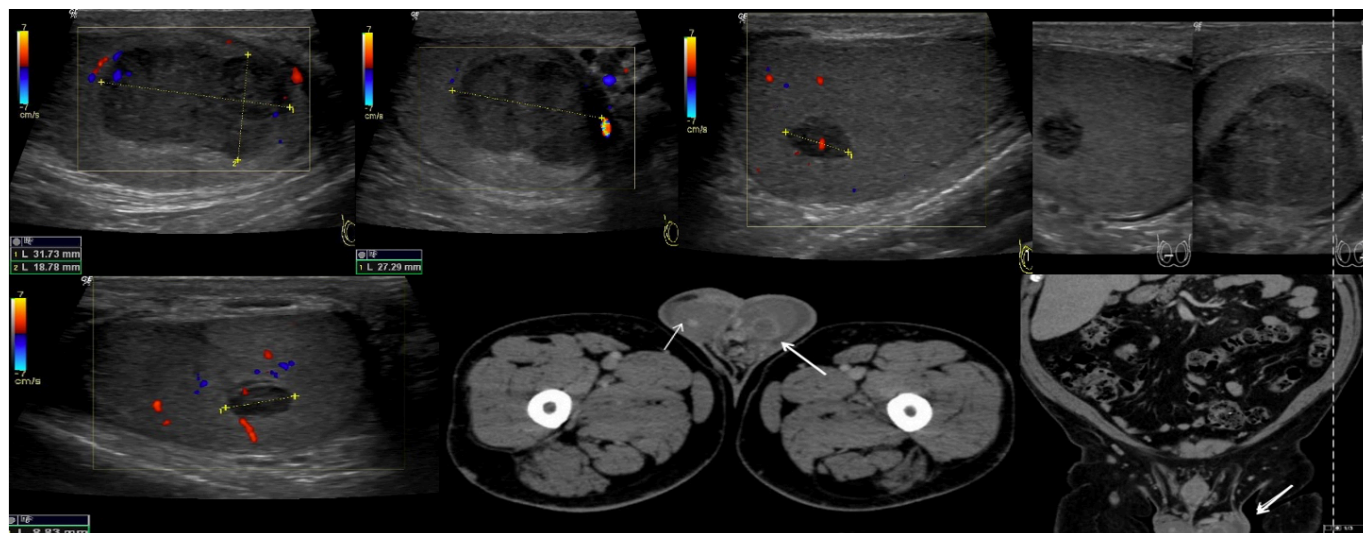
Ultrasound images demonstrating bilateral hypoechoic nodules, while axial and coronal CT scans reveal bilateral testicular nodules.
